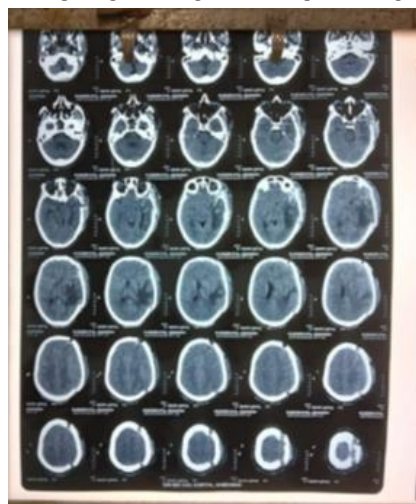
Post operative CT scan showing elevated temporalis hinge bone flap to accommodate edematous brain.
